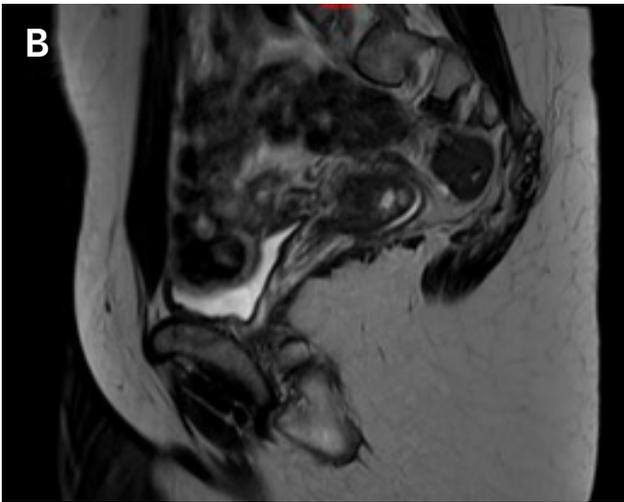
MRI. T2 Sequence in sagittal section.
